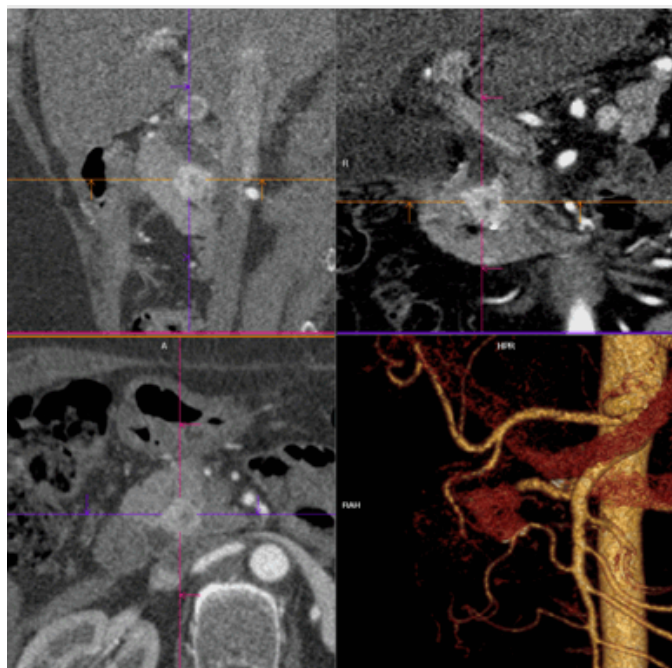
A follow-up computed tomography scan revealed tumor volume reduction; a small, hyperdense focus within the lower pole of the tumor, visible in the sagittal section, apparently corresponded to the embolic material.
